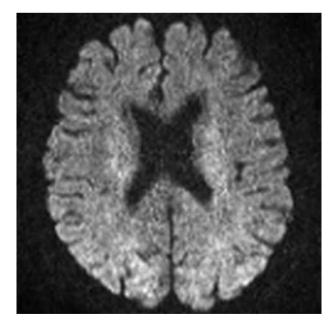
Diffusion-weighted magnetic resonance imaging performed on day 3 after the procedure, showing no ischaemic lesions
